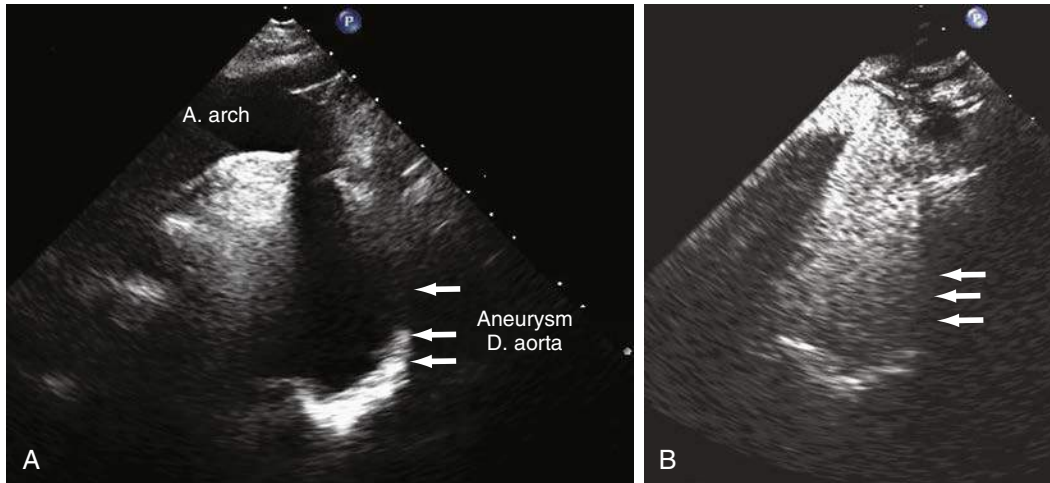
A, Two-dimensional transthoracic echocardiography (2D TTE) from suprasternal view; repaired coarctation of the aorta (CoA) with aneurysmal dilation of D. aorta (white arrows). B, Same view after injection of echocardiographic contrast (SonoVue), aneurysm dilation of the D. aorta is clearly demonstrated (white arrows). A. arch, Aortic arch; D. aorta, descending aorta.
